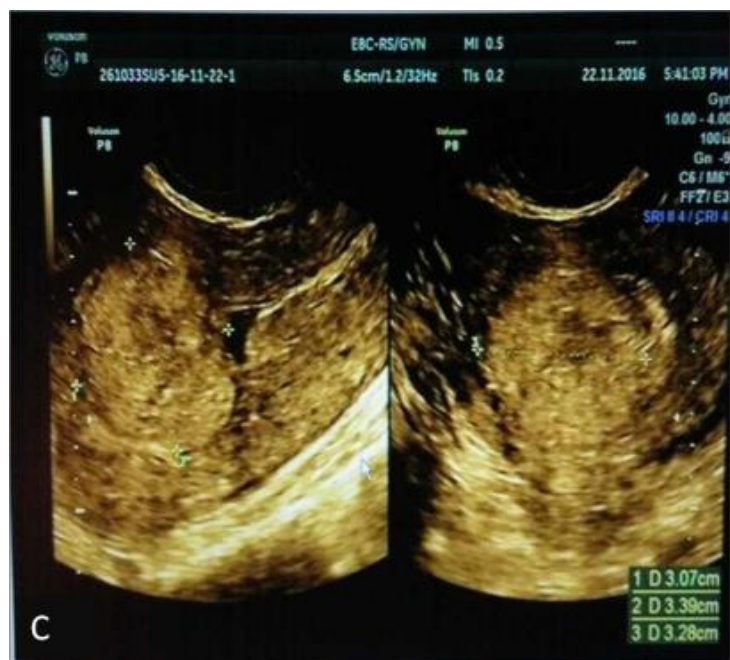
Pelvic B-ultrasound (before chemotherapy)
